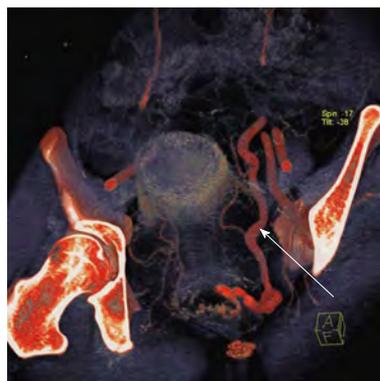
Computed tomography angiography image (post processed with volume rendering technique) showing rectal arterio-portal fistula draining into dilated superior rectal vein (arrow).
